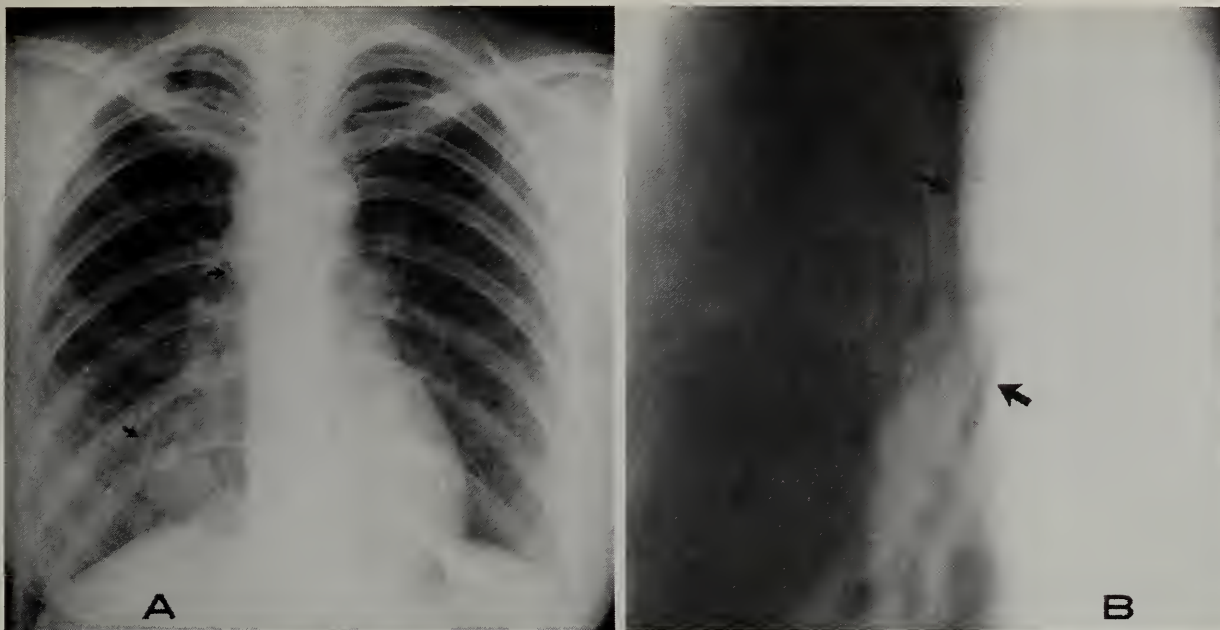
The patient is a 27-year-old woman with cough, chest pain and intermittent fever for one year. Chest x-ray showed right paratracheal adenopathy (upper arrows), fullness of the right hilum, and infiltrate at the right base. A frontal tomogram demonstrates narrowing of the bronchus intermedius (lower arrow). Upper arrows outline paratracheal adenopathy. Bronchoscopy revealed occlusion of the right middle lobe orifice by biopsy-proven granulation tissue. Tissue cultures yielded *C. immitis*. Complement fixation was positive at 1:32, as was the precipitins at 1:10.
